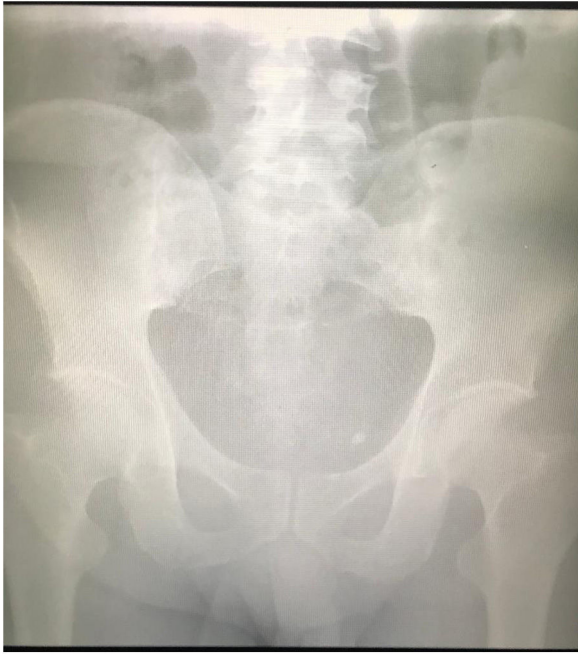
Plain (anteroposterior oblique) radiograph of the sacroiliac joint, showing ankylosis, pseudo-widening, and subchondral sclerosis in the right sacroiliac joint (grade 3 sacroiliitis) and subchondral sclerosis pseudo-widening in the left sacroiliac joint (grade 2 sacroiliitis).
